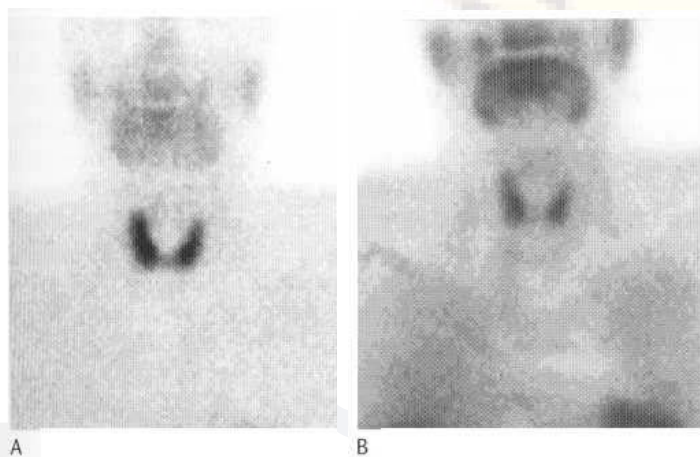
Thyroid/parathyroid scintigraphy. Normal thyroid uptake of $^{99m}\text{TcO}_4$ (A) and $^{99m}\text{Tc-MIBI}$ (B). (Note: the normal parathyroids are not visible.)
